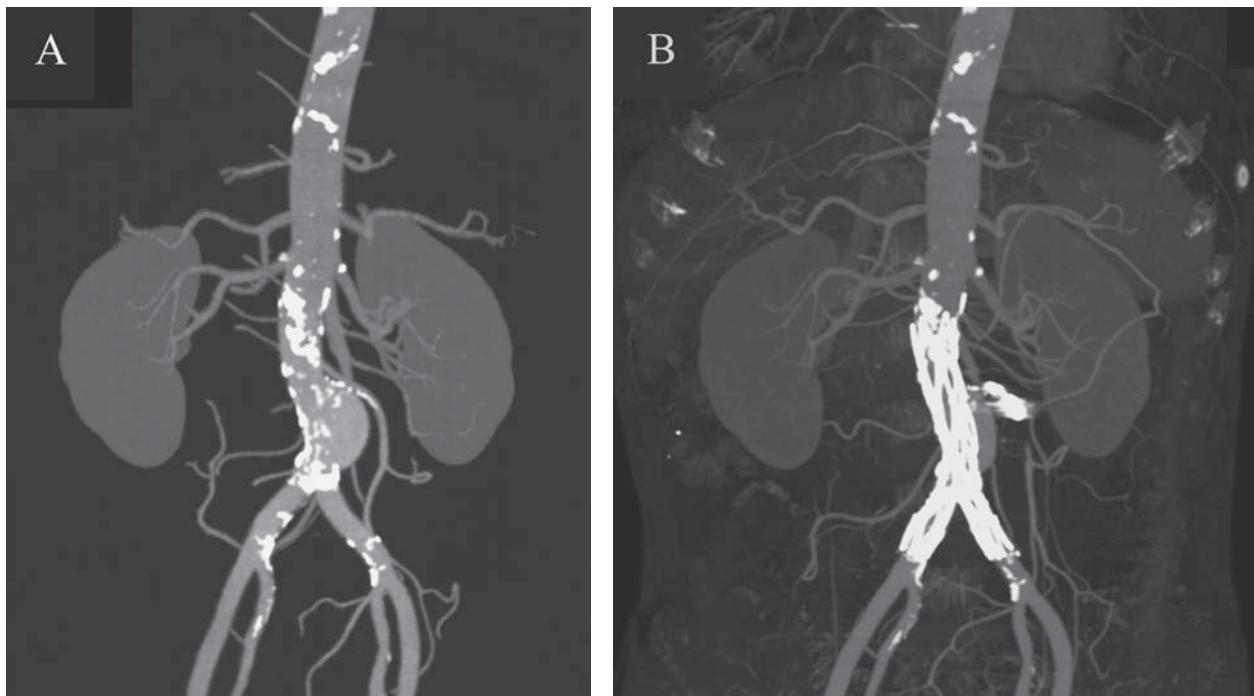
Computed tomography angiography of the aorta. (A) Before the operation. (B) After endovascular stent grafting.
